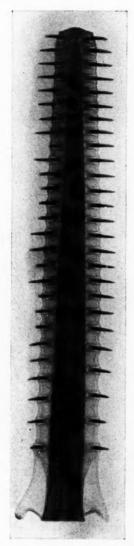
Radiograph o beak of sawfish.
